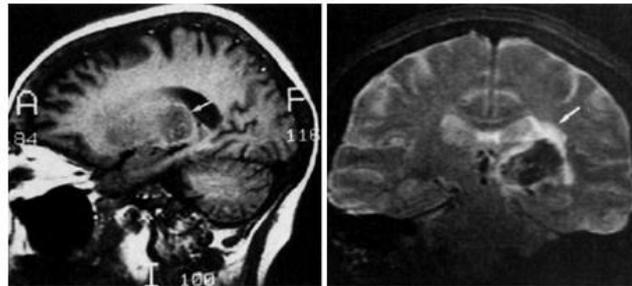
Sagittal T1-weighted MR Image (left) & Coronal T2-weighted MR Image (right) of Hypertensive Intracranial Haemorrhage [12]
